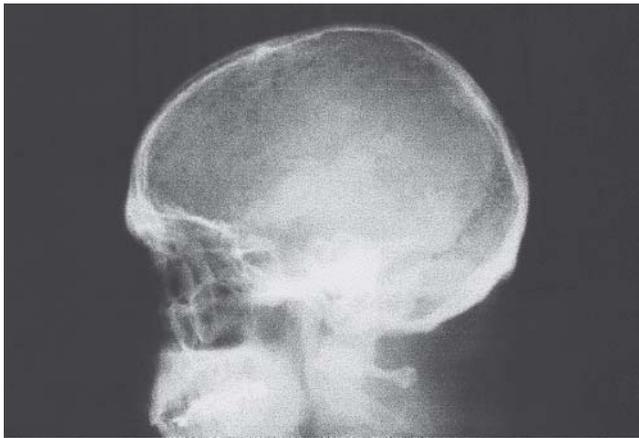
Radiograph showing lytic bone lesions of the calvarium.
